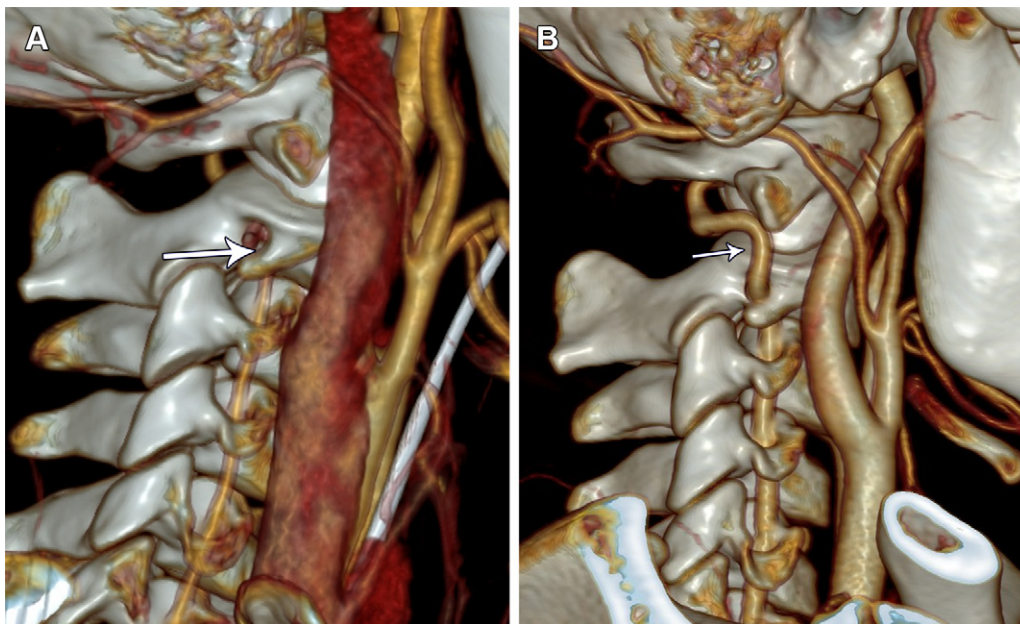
Right vertebral arterial occlusion, which was resolved at follow-up imaging, in an 8-year-old boy. (A) Right lateral volume-rendered CT angiogram on day 3 after clinical presentation shows occlusion (arrow) of the right vertebral artery at the C2 level. (B) Follow-up right lateral volume-rendered CT angiogram on day 410 shows a normal appearance of the right vertebral artery (arrow).
